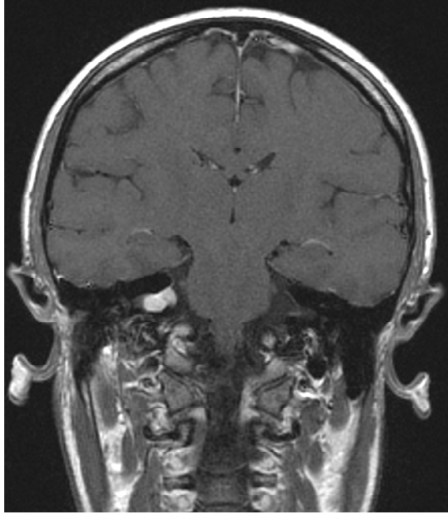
Coronal MRI brain scan of K.M. Within the right temporal bone (on the left of the scan) AN is visible as a rectangular prolonged whiteness
